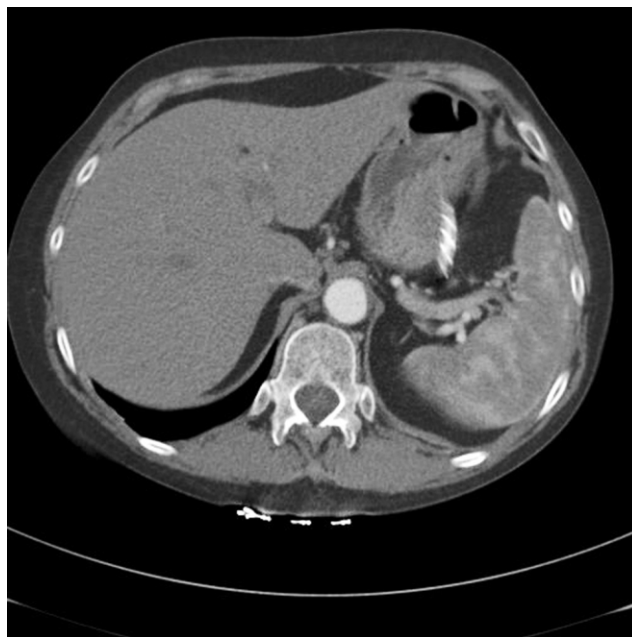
Spiral CT angiogram demonstrating well perfused spleen, satisfactory position of grafts with no endoleak at 4 months.
